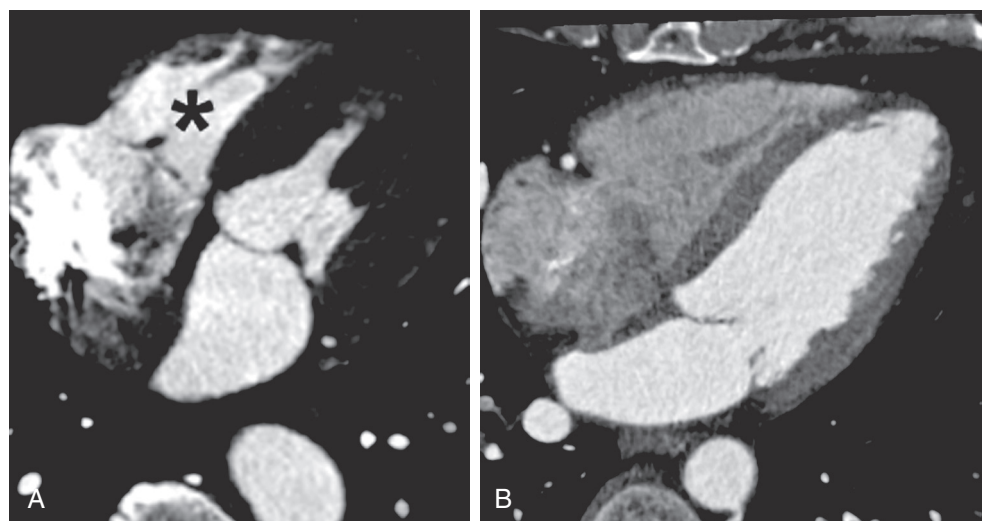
Timing of arrival of radiocontrast medium within the right side of the heart. In A, timing was early because contrast was still contained within the right atrium and right ventricle (asterisk). This may be desirable if delineation of right-sided cardiac structures is necessary, but in general, cardiac CT usually is timed after contrast has passed through the right side of the heart, leading to a levo-phase image, as shown in B.
